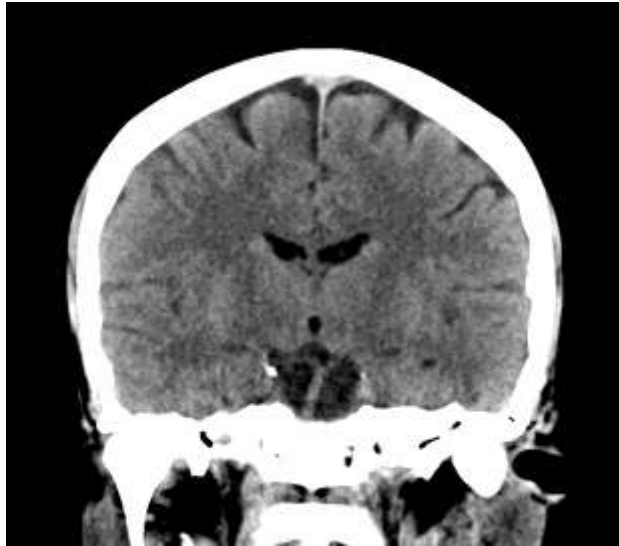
11. normal CT brain in coronal section(radiopedia)
